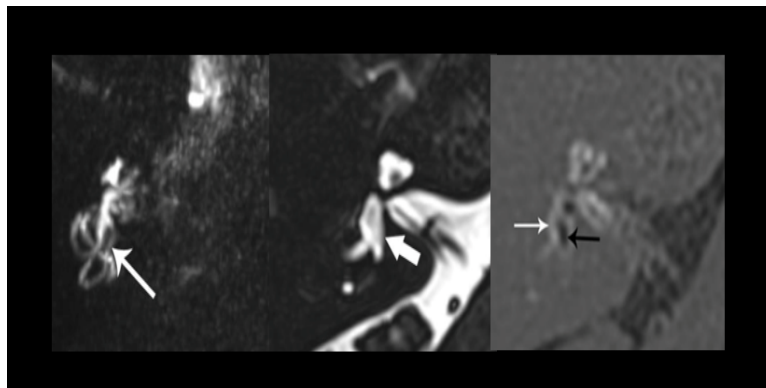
High spatial resolution 3D-FLAIR MR imaging of a normal cochlea without endolymph hydrops. From left: Maximum intensity projection (MIP) image visualizing the hyperintense perilymph. T2 image visualizing the total lymph space. Subtracted image showing hypointense endolymph surrounded by hyperintense perilymph [56].*
